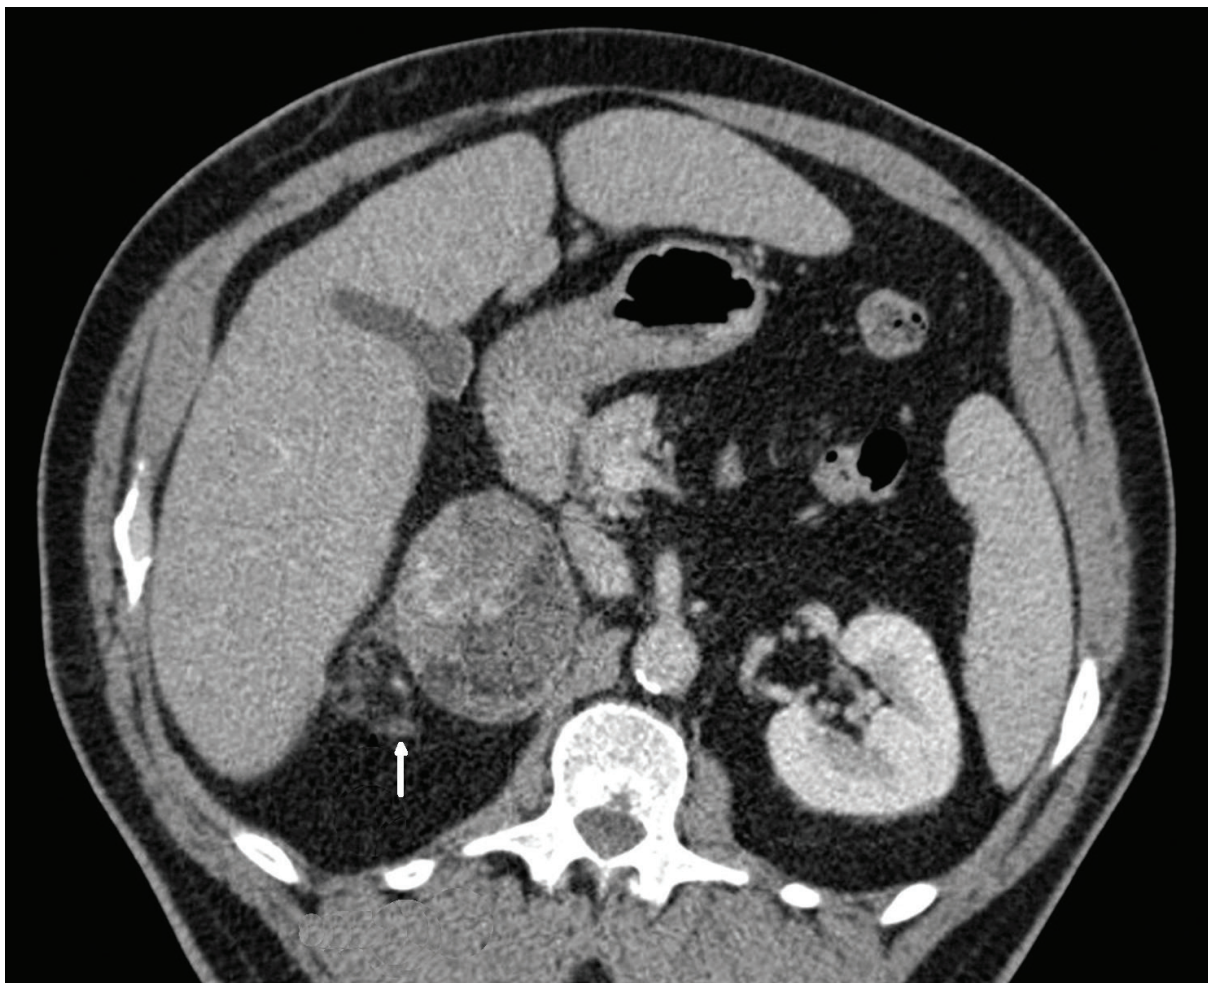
Adrenocortical carcinoma with mineralocorticoid activity in right adrenal gland showing typical heterogeneous appearance and local invasion (arrow) (CT scan).
